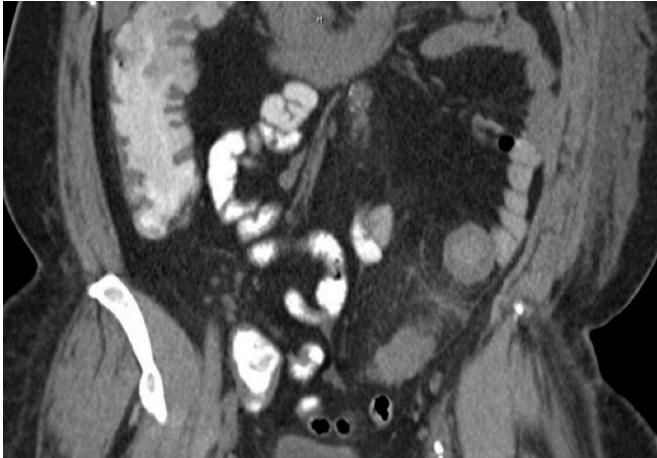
CT scan showing mild sigmoid colitis and wall thickening.
